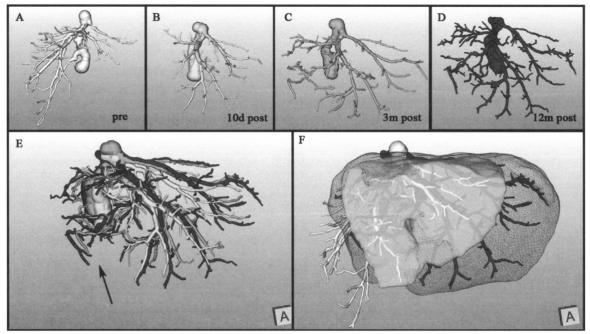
The registration of vascular structures from the different time points allows for additional evaluation of vascular substructures and dependent territories more precisely than with the images side by side (hepatic veins; A–D). In this donor, collaterals can be found in CT data 3 and 12 months after transplantation but not in the first postoperative scan (B and E, *arrow*). The shape deformation of the remnant can be compared for different time points more carefully when the rotation of the organ itself is removed (F, pre-OP remnant bright, 12 months post-OP dark).
